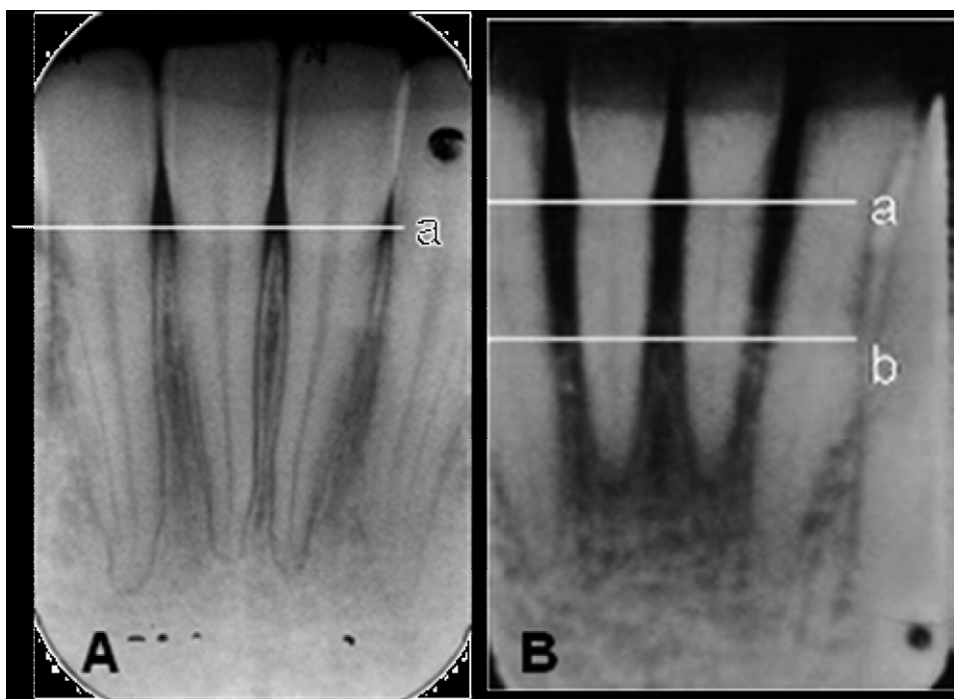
In periapical x-ray A, marginal bone levels (line a) are consistent with no history of periodontitis. In periapical x-ray B, periodontitis has caused resorption of approximately 50% to 60% of the bone supporting the mandibular anterior teeth. The approximate level of bone that would be expected in the absence of periodontitis is marked by line a, and the approximate level at the time of the x-ray is marked by line b.
